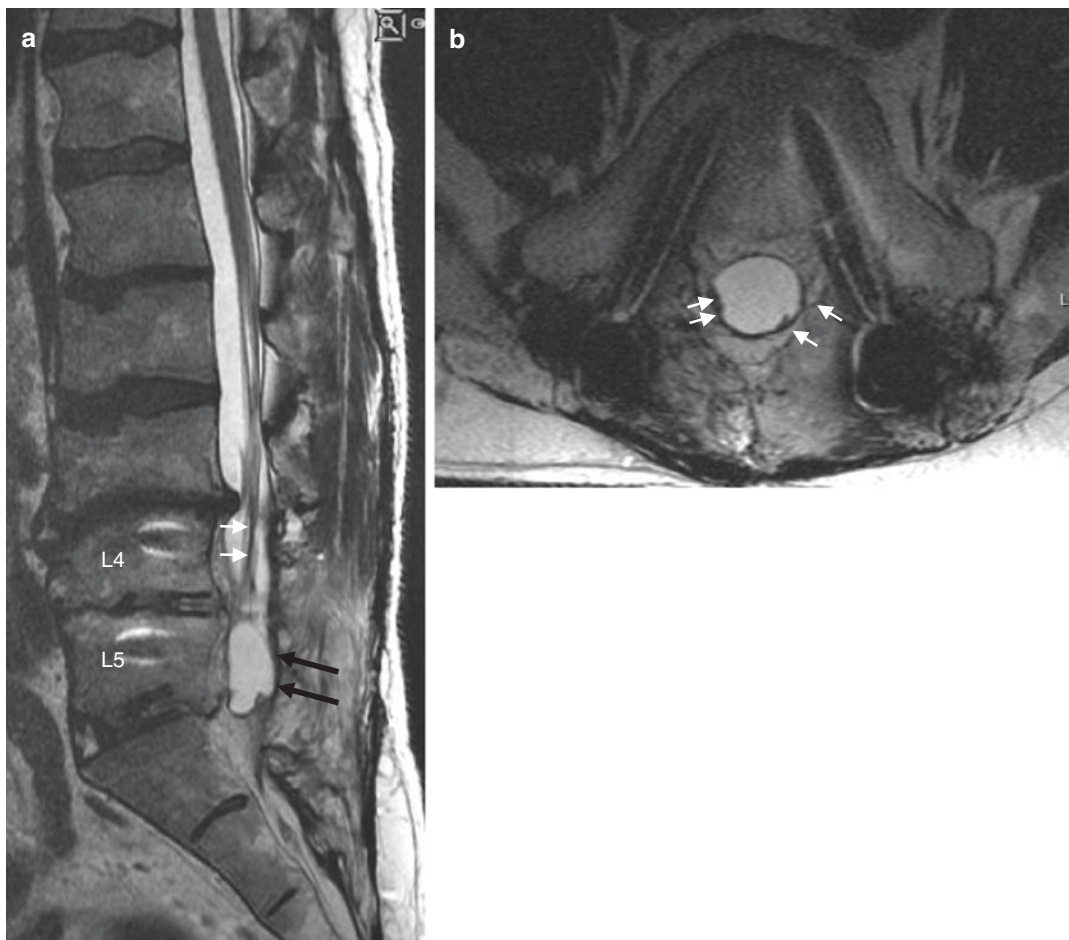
A 70-year-old man with chronic back pain 1 year after lower lumbar midline laminectomy and posterolateral arthodesis. Sagittal T2-weighted MR image (a) demonstrates apparent clumping of nerve roots at L4 (white arrows) and an “empty thecal sac sign” (black
